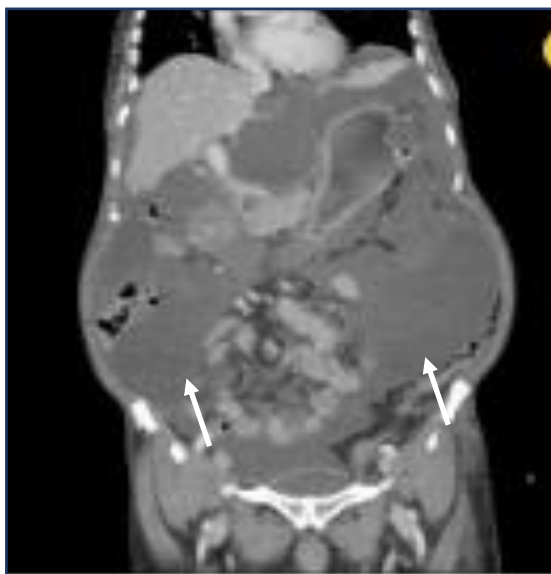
CT abdomen shows mucinous fluid in the abdomen "Jelly-belly"
